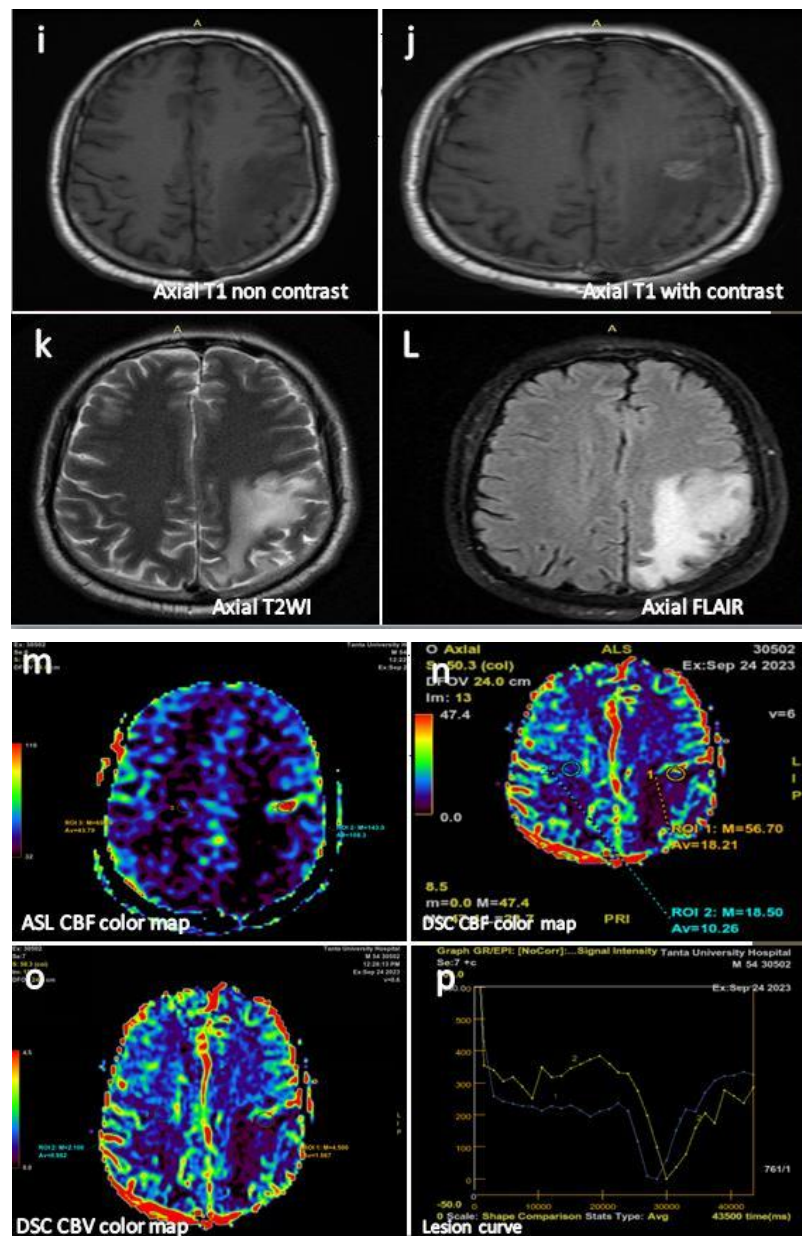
Higher axial MRI cuts of the brain in the same patient show another newly-developed enhancing non-hemorrhagic lesion in the left parietal lobe, displaying low signal on T1WI, high signal on T2WI and FLAIR sequence, measuring about 1.6 x 1.5 cm in its maximum dimensions with extensive peri-focal edema and both exert mass effects in the form of effacement of the overlying cortical sulci (i-l). ASL and DSC color maps show a hyperperfused lesion in comparison with the contralateral normal brain white matter. ASL r CBF=1.1, ASL CBF absolute value = 143 ml/100 gm/min, DSC r CBF =2.9, DSC CBF absolute value = 56 ml/100 gm/min, DSC r CBV =2.7(m-o) and the lesion signal to time curve shows rapid signal drop and peaking with rapid upward rise compared to contralateral white matter curve (yellow and blue curve in p respectively).
